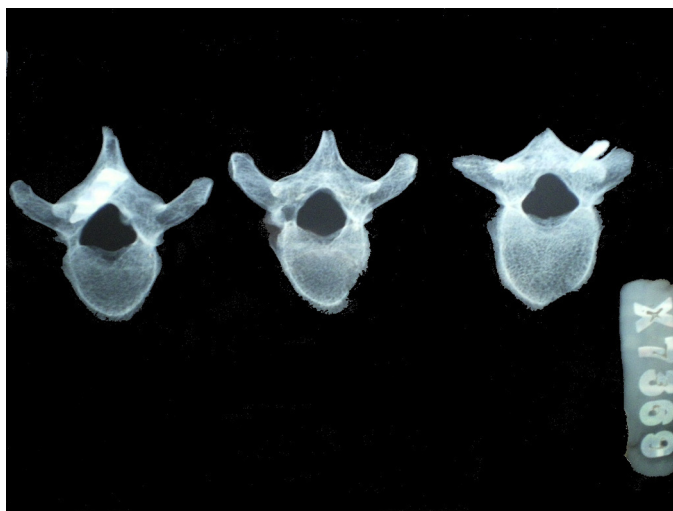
Wet film radiograph of vertebrae showing projectile injury (MIN86 5343).
